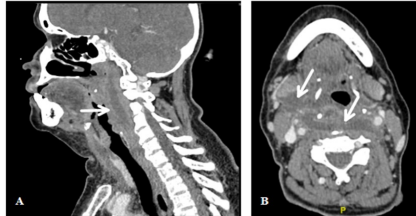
(A) CT neck in sagittal cut demonstrating downward spread of retropharyngeal abscess (arrow). (B) CT neck in axial cut showing abscess extending from retropharyngeal space (arrow) into right submandibular (arrow) and sublingual space during initial presentation.
